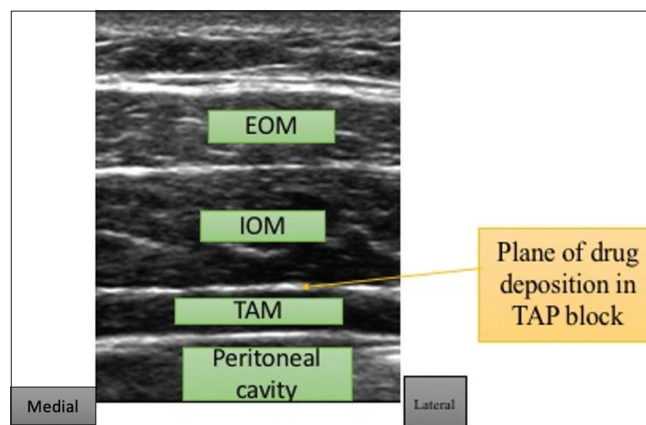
Ultrasound view of abdominal muscles and TAP block (EOM—External Oblique muscle, IOM—Internal Oblique Muscle, TAM—Transversus Abdominis Muscle)
